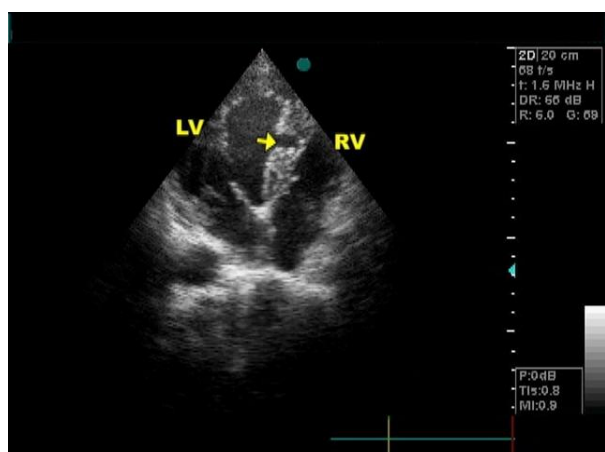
TTE apical 4C view shows the U-shaped, slit-like appearance of the cleft in mid interventricular septum
